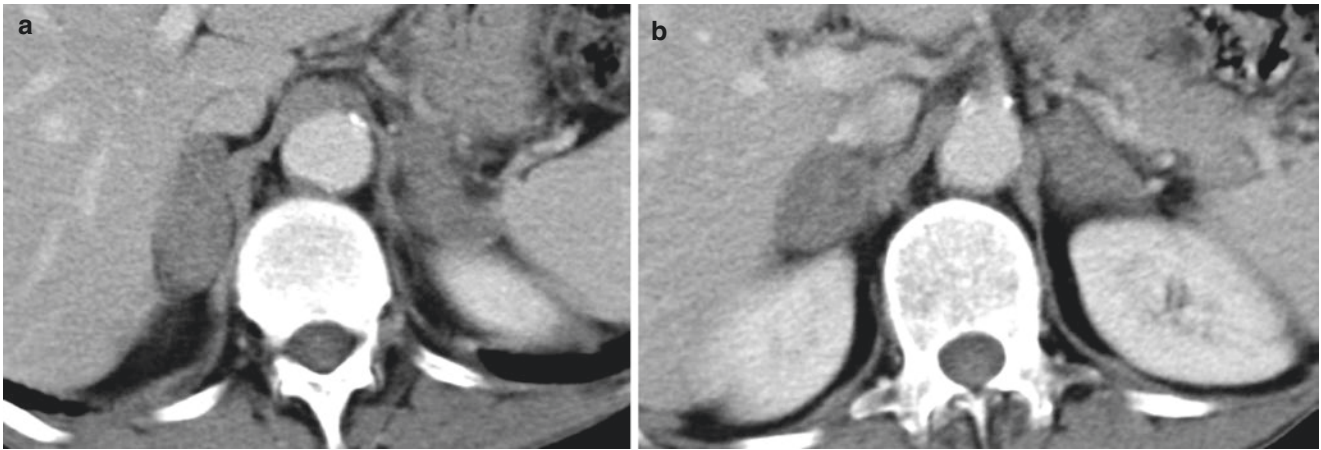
Primary adrenal insufficiency due to fungal disease (paracoccidioidomycosis). Axial post-contrast CT showing enlargement of both adrenal glands (*white arrows*)
